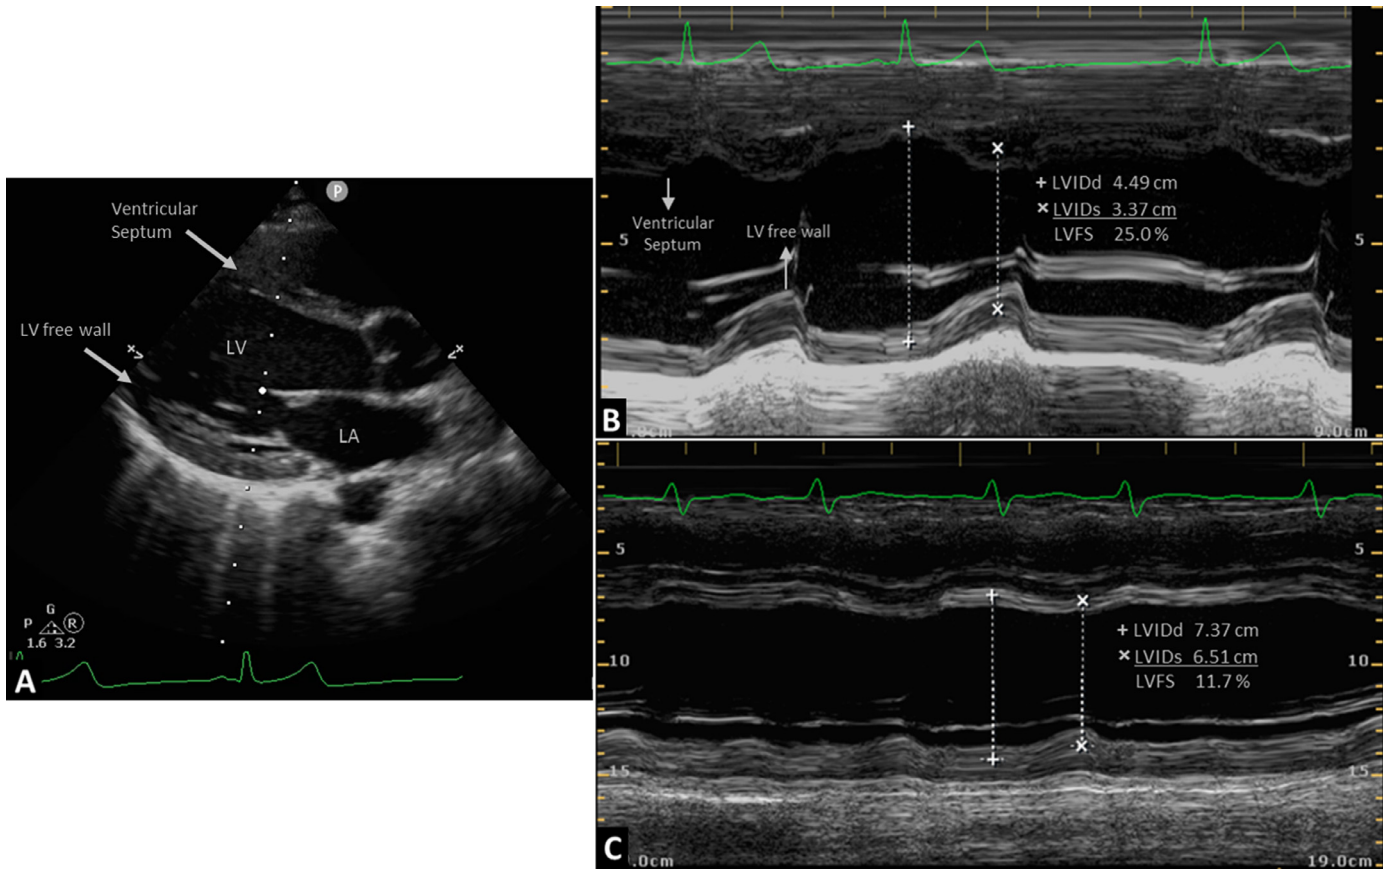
Midwall left ventricular fractional shortening by transthoracic echocardiography. (A) Two-dimensional image of parasternal long-axis view describing the image acquisition before M-mode imaging of midwall left ventricular fractional shortening; the M-mode line (white dotted line) is placed through the ventricular septum (upper arrow, passing below the tip of the anterior mitral leaflet) and the left ventricular free wall (lower arrow); then, M-mode imaging can be recorded. (B) M-mode image of normal midwall left ventricular fractional shortening (25.0%) suggesting normal left ventricular systolic function. The ventricular septum (upper arrow) and the left ventricular free wall (lower arrow) are depicted across several cardiac cycles. (C) M-mode image of abnormal midwall left ventricular fractional shortening (11.7%) suggesting left ventricular systolic dysfunction. LA, left atrium; LV, left ventricle; LVFS, left ventricular fractional shortening; LVVIDd, left ventricular internal diameter at end-diastole; LVVIDs, left ventricular internal diameter at end-systole.
